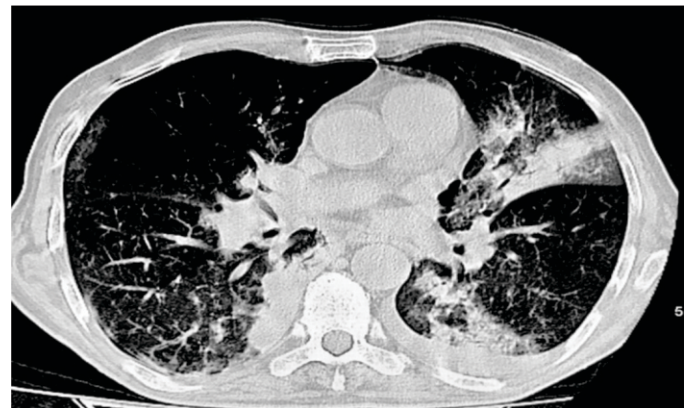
Axial Sections of HRCT Performed in 84 years male who presented with cough and dyspnea with decreased oxygen saturation.
